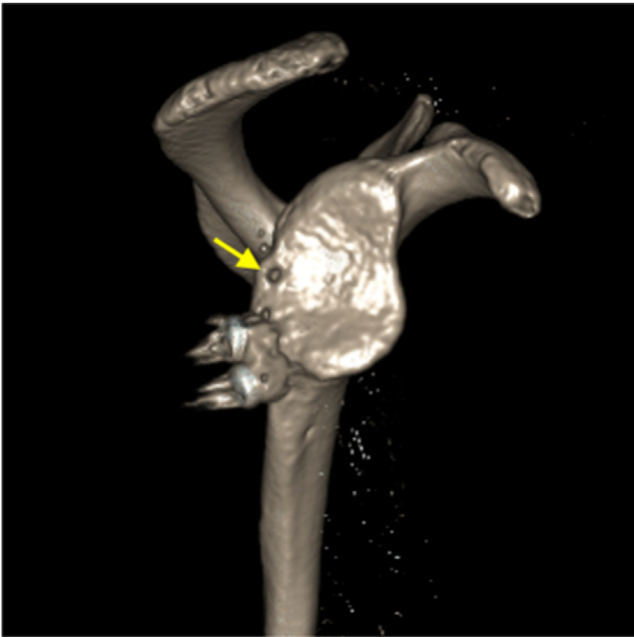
Postoperative computed tomography scan with 3D reconstruction with an en-face view of the posterior glenoid bone block reconstruction. The distal clavicle bone-block was secured with 2 suture buttons. Arrow: pilot hole for posterior capsulolabral repair, superior to graft.
